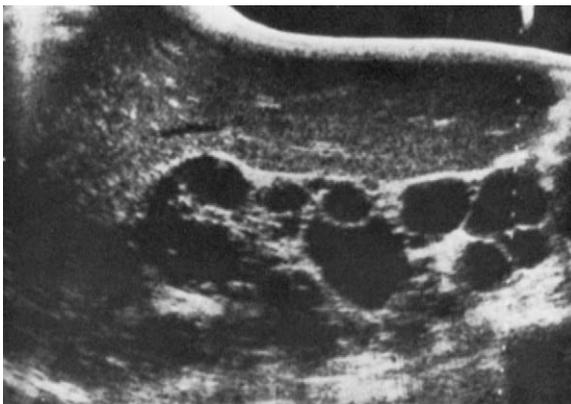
Adult polycystic kidney disease. Longitudinal scan of right kidney demonstrates the classic appearance of multiple cysts of varying shape and size. (From Scheible W, Talner LB. Gray scale ultrasound and the GU tract. *Radiol Clin N Am* 1979;17:288; with permission.)
